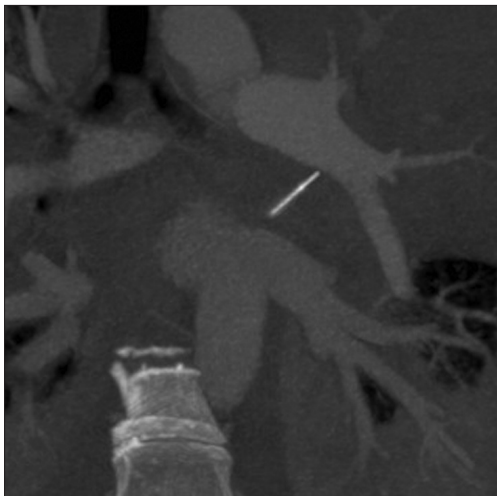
An enlarged image of the previous CT scan
